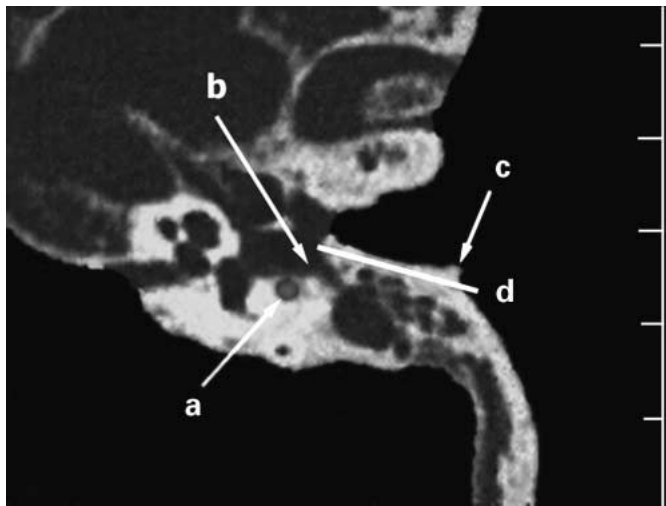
High-resolution CT scan: the existence of sufficient space for the safe drilling of the direct tunnel can be predicted preoperatively: (a) facial canal, (b) facial recess, (c) Henle's spine and (d) direction and place of drilling the direct tunnel.
